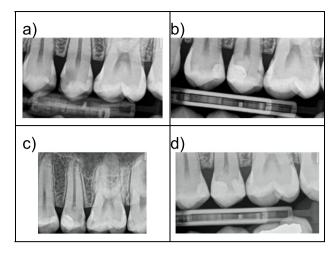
a–d Radiography of one PE (pulp exposure) case with vital pulp and dentin bridge formation a preop b immediately after treatment c 2 years follow-up periapical radiography (cavity formation at distal side) d 2 years follow-up bite-wing radiography after the restoration of the cavitation
